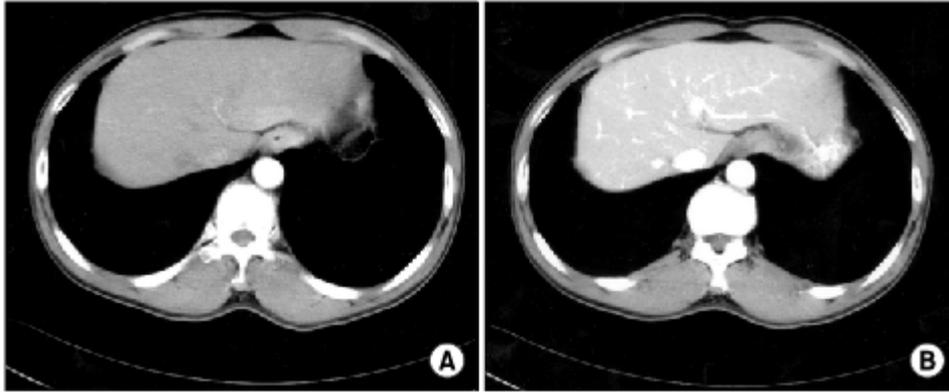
Computed tomography showing 2 cm sized single lesion in segment 3 of liver. In arterial phase (A) the lesion has high attenuation without well demarcation, and in portal phase (B) the lesion has low attenuation with well demarcation.
